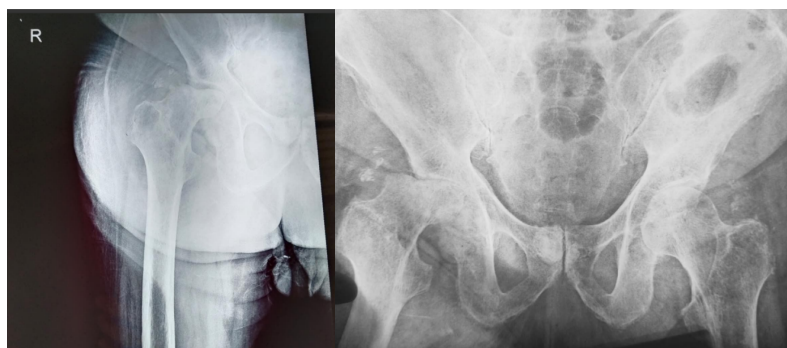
Radiographs suggestive of right side osteoarthritis of hip
